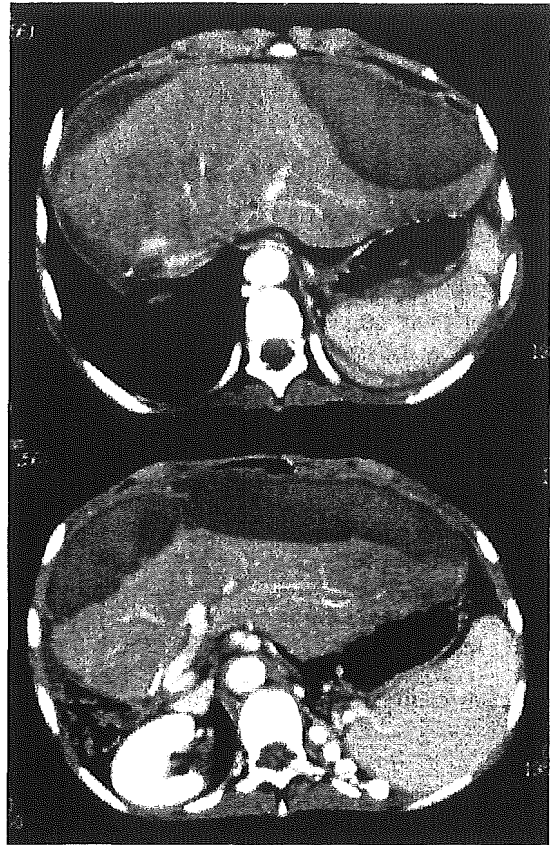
Contrast enhanced computed tomography scan at 35 days after LT shows subcapsular hematoma with nonperfused areas equivalent to 36% of the extended left lobe liver graft.
